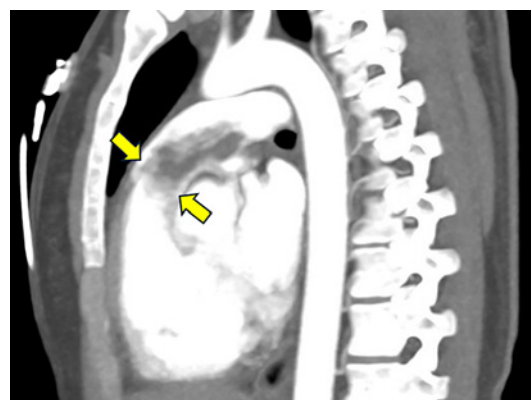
Sagittal CT angiography of the chest. Protrusion of the proximal end of the mass within the pulmonary artery toward to the right ventricular outflow tract, demonstrating criteria 2 of wall eclipsing sign.
